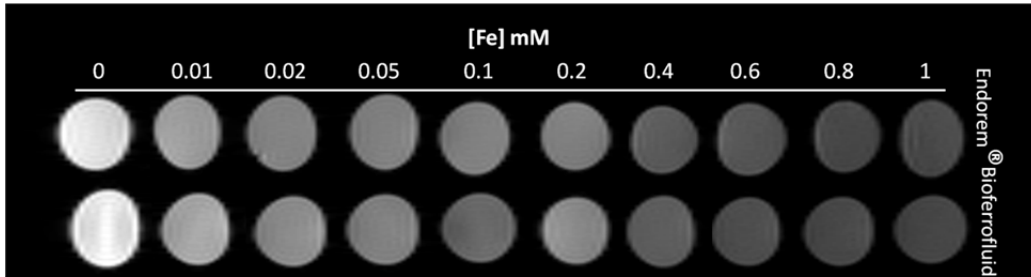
T_2 -weighted MR imaging of bioferrofluids and Endorem® in physiological saline at different iron concentrations (in mM).
